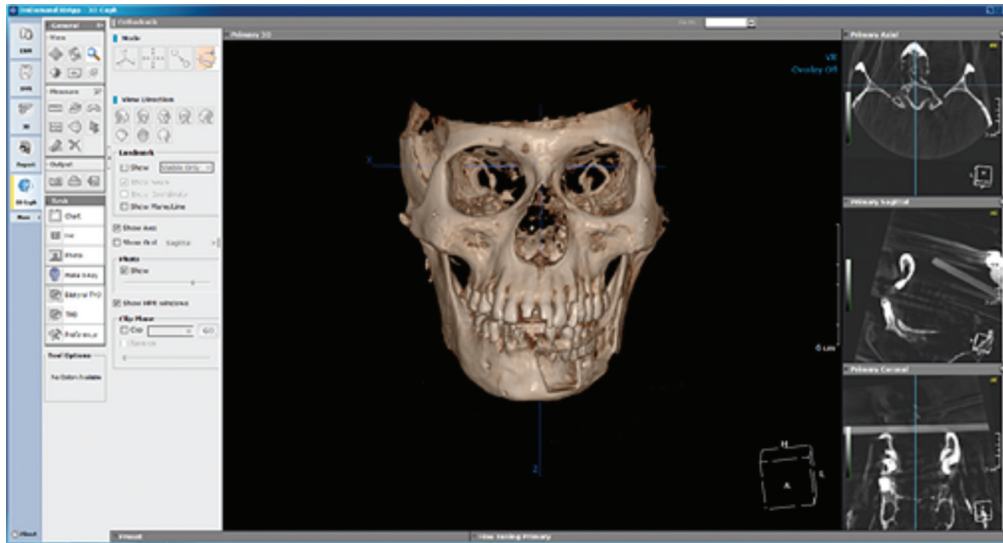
Reconstructed three-dimensional cone-beam computed tomography images by OnDemand 3D™.
